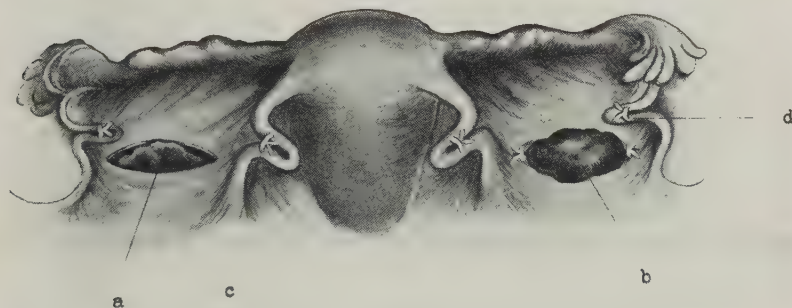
ÖÖPHOROPEXY FOR PROLAPSED OVARY BY ITS TRANSPOSITION THROUGH THE INCISED BROAD LIGAMENT, AND ITS ANCHORAGE UPON A HIGHER LEVEL OF THE ANTERIOR ASPECT OF THE LIGAMENT (Mauclaire) — COMBINED WITH SHORTENING OF THE ROUND AND INFUNDIBULOPELVIC LIGAMENTS FOR RETRODISPLACED UTERUS (Barrows) — as explained in the text.
